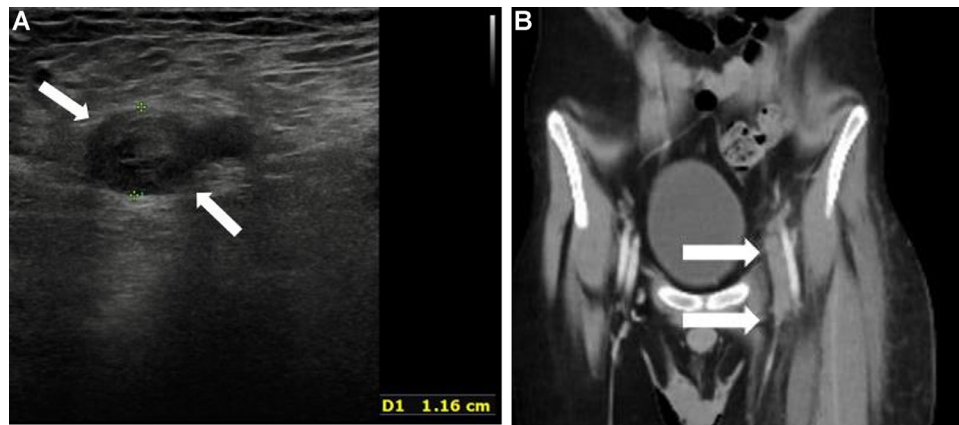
(A) Sonographic image of the right common femoral vein showing noncompressible intraluminal hypoechoic material and dilation (arrows), compatible with deep venous thrombosis. (B) Coronal CT reconstruction showing a portion of the extensive left lower extremity DVT, extending from the bifurcation of the left common iliac vein to the popliteal vein, including the common femoral vein (arrow).
